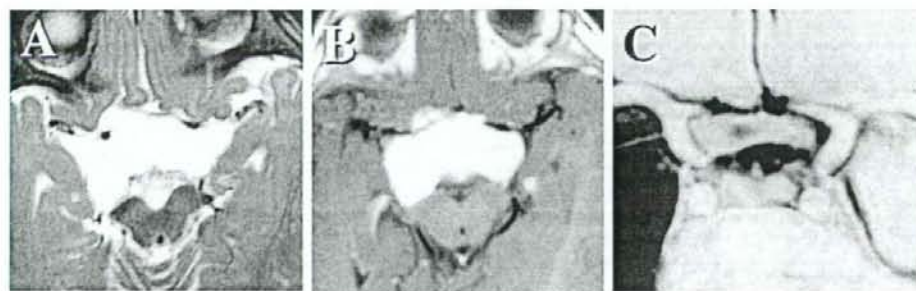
MR images of a 1-year-old patient demonstrate typical appearance of pilocytic astrocytoma. T2-weighted axial image (A) shows a high-signal intensity suprasellar mass that is homogeneously enhanced with gadolinium contrast on T1-weighted image (B). After six cycles of chemotherapy, the tumor almost completely disappeared on usual MR images; however, a coronal image of three-dimensional MR cysternography (C) depicted a tiny residual tumor within the right side of the chiasm.
